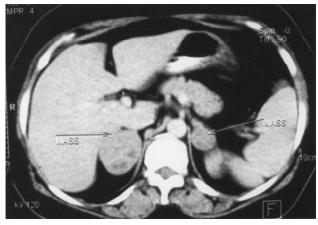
Contrast-enhanced CT scan of the abdomen showing bilateral adrenal masses.
